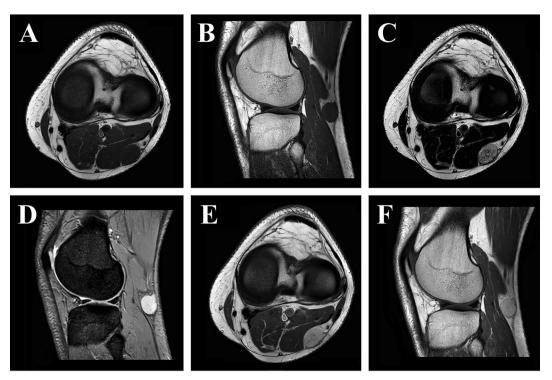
Magnetic resonance imaging of the left knee in a 42-year-old man presenting with a painless swelling lesion for a year demonstrating a well-circumscribed, capsulated soft tissue mass isointense to the muscle on T1-weighted images (A, B), hyperintense on T2-weighted scan (C) and hyperintense on multicho fast field echo T2-weighted image (D). On post-contrast sagittal and axial T1-weighted images (E, F), the tumor showed homogeneous gadolinium enhancement. The patient underwent uneventful surgical resection.
